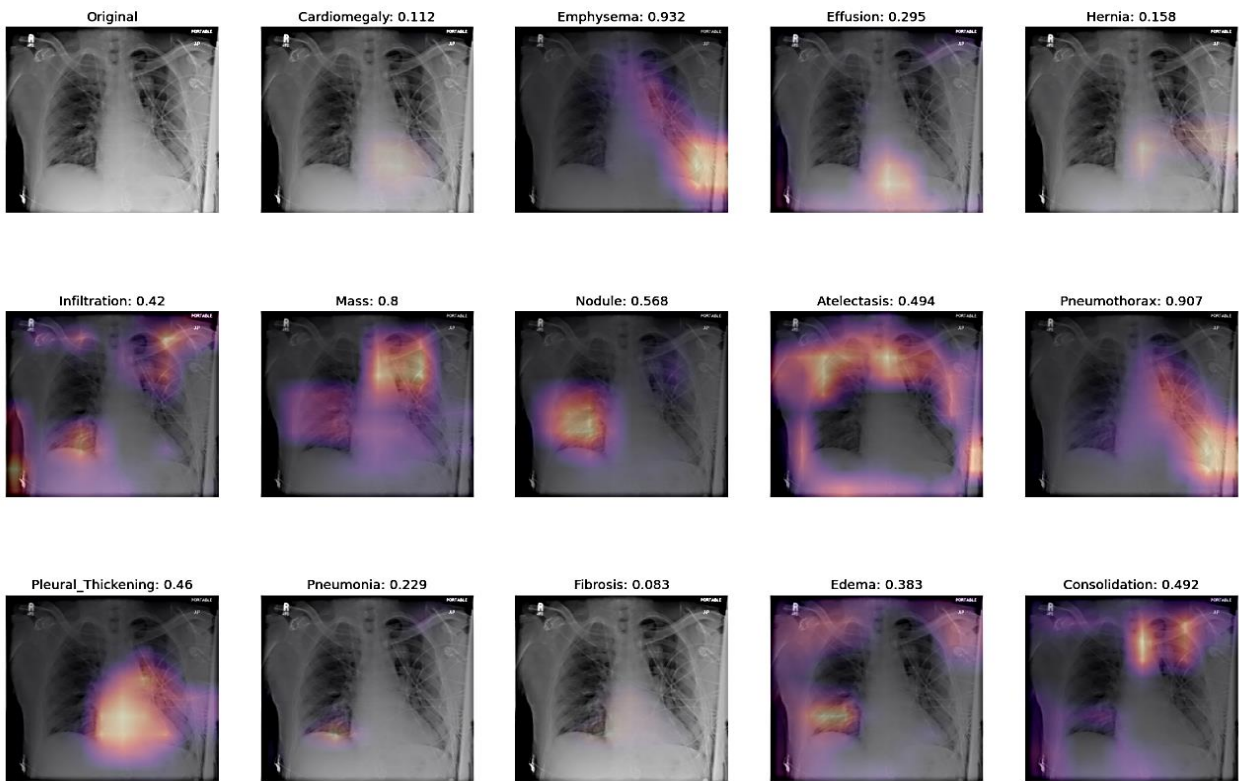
Chest X-ray classification results for potentially life-threatening cardiac conditions for Case Study 4
